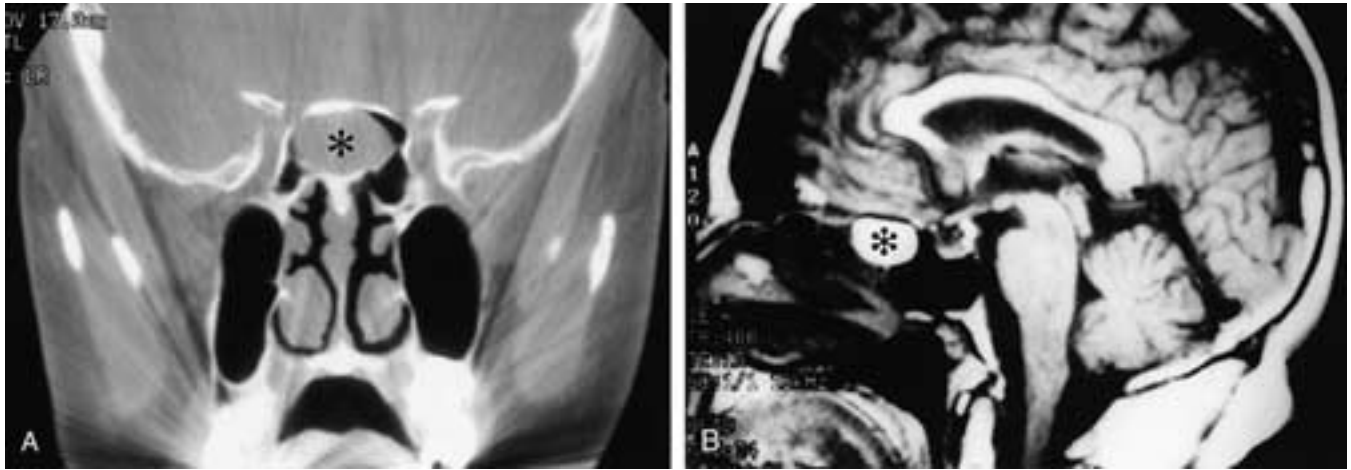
Nasal septal air cell. A, Coronal CT image demonstrates an expansile mass in the anterior sphenoid sinus (*asterisk*). B, Sagittal T1-weighted MR image displays the hyperintense inflammatory mass (*asterisk*), which is well separated from the intracranial compartment. This was proven to be a mucocoele within a posterior nasal septal air cell.
